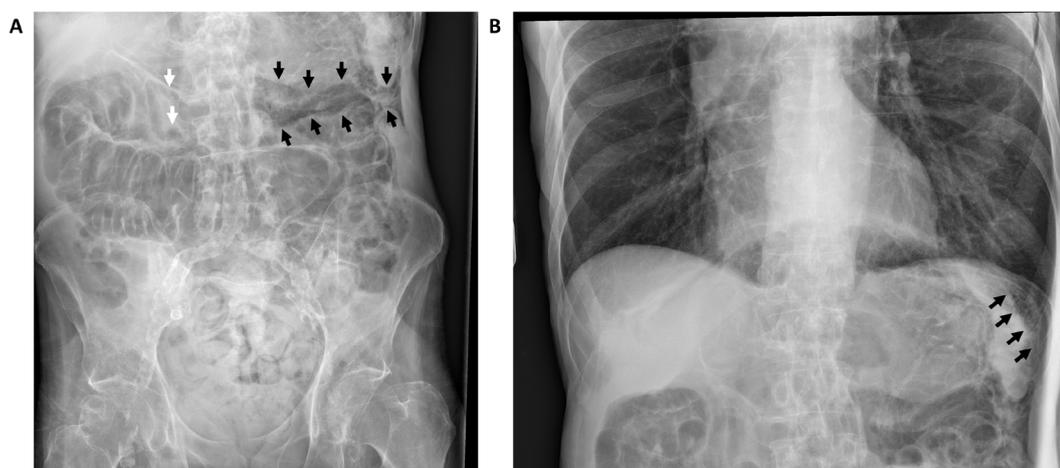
(A) and (B) Upright abdominal radiograph in panel A with subdiaphragmatic detail in panel B. Note the distended colon transversum, loaded with air. White arrows indicate intramural air. Black arrows indicate pneumoperitoneum.
